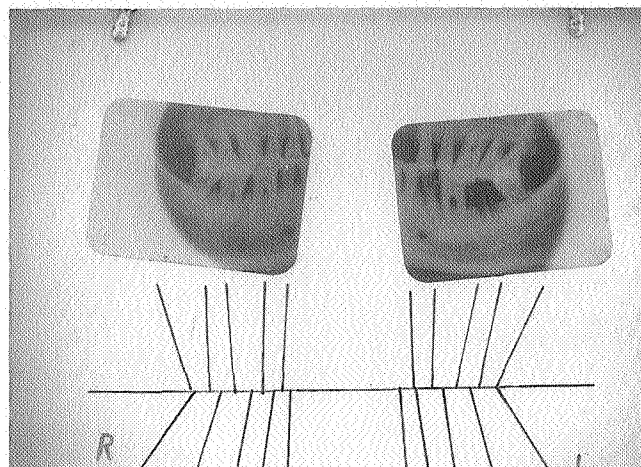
Posterior bitewing x-rays with tracing of the long axes of the teeth
